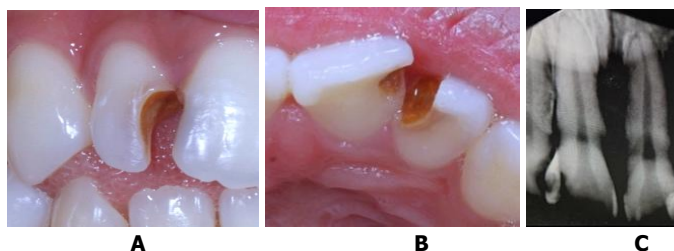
A. The clinical view of teeth #11 and #12 labial view. B. The clinical view of teeth #11 and #12 palatal view. C. Radiographs of teeth #11 and #12 before treatment.
